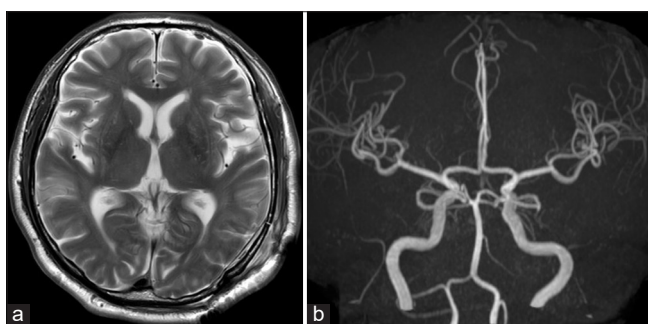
(a) Postoperative T2-weighted magnetic resonance imaging showing rapid improvement of the edema. (b) Magnetic resonance angiography revealing the elimination of the shunt.
